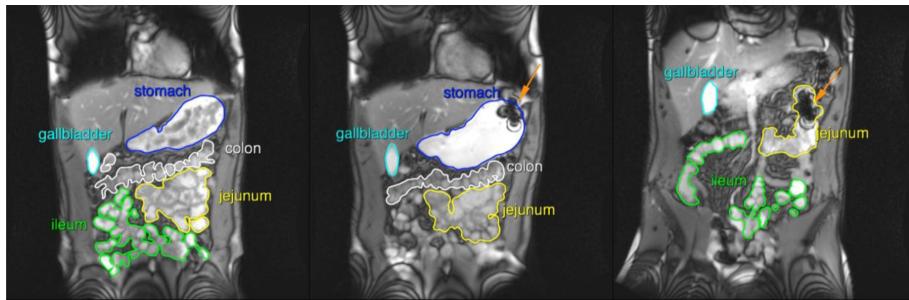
Exemplary abdominal MR images of one subject obtained by using T1/T2-weighted TRUFI sequence. The presented images were taken before (left), 2 min after (middle) and 195 min after capsule intake (right). The capsule could easily be detected by the artefacts caused by iron oxide (orange arrows). The different parts of the gastrointestinal tract are also highlighted in this figure.
